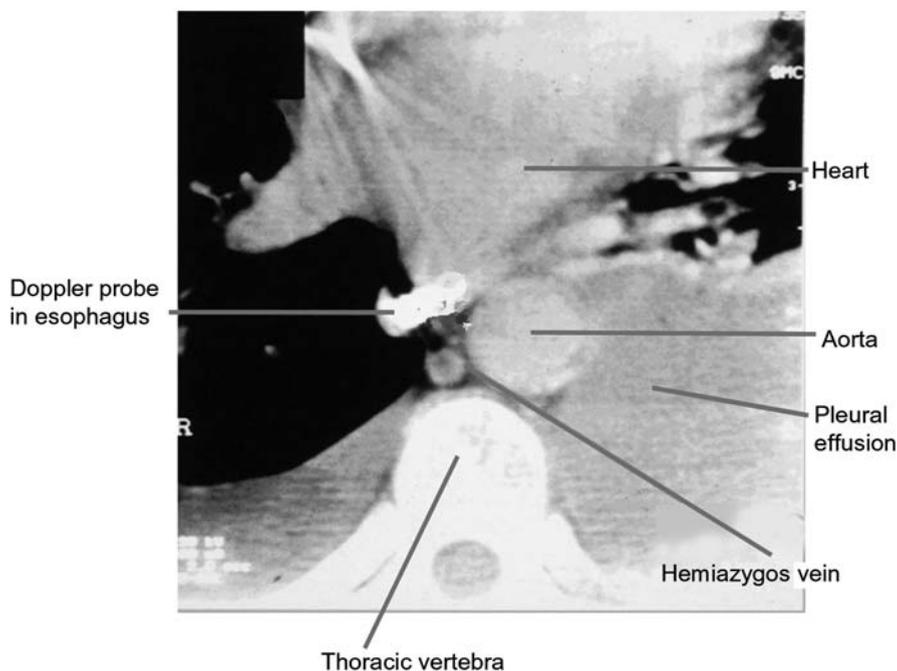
CT scan indicating thoracic anatomy and proximity of esophageal Doppler probe to descending thoracic aorta
